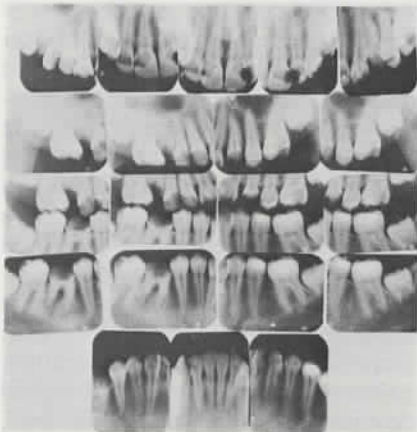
Bite wing and periapical radiographs at age 15.
